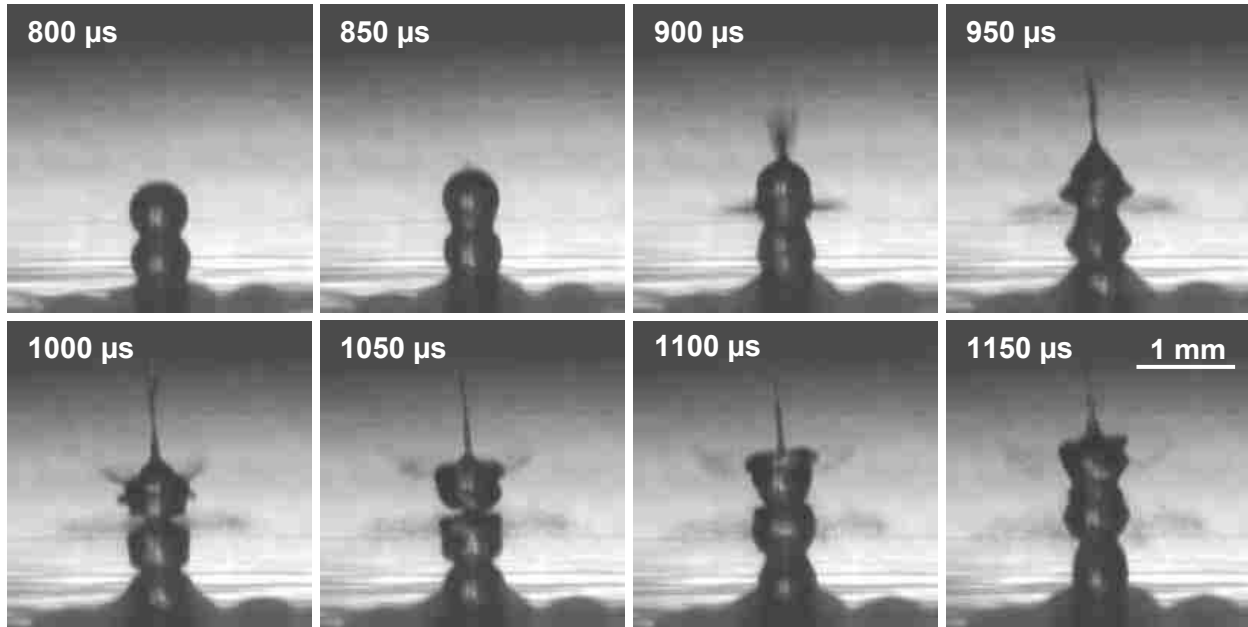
Frames taken from the high speed video (20,000 fps) of n-propanol at 365 W/cm² ($p_+ = 4$ MPa, $p_- = 3$ MPa). The first frame taken at 0.8 ms shows the drop chain. In the second frame (taken 50 μ s after the first frame) the top droplet of the chain is already starting to atomize, as seen by the shading just above the droplet. The third frame shows triangular atomization, which is very similar to what was observed in water. The triangular atomization causes more atomization to occur at the 1 ms time point. The total ultrasonic exposure time was 10-ms.
